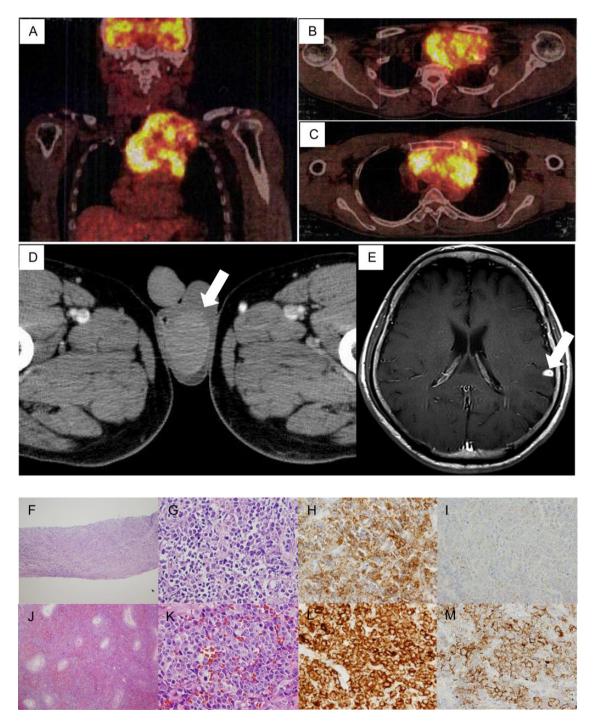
FDG-PET/CT showed remarkable FDG uptake in anterior mediastinum (A-C). CT revealed right testicular swelling (D). Head MRI showed multiple parenchymal invasions (E). Mediastinal sections at low (F) and high (G) magnifications showed diffuse infiltration of medium-sized tumor cells with scant cytoplasm and dense chromatin, which was accompanied by nuclear fragmentation. The tumor cells were positive for CD56 (H) and CD99 (I). Testicular mass sections at relapse showed diffuse stromal infiltration of medium- to large-sized atypical cells with no apparent differentiation to neutrophils or monocytes (J and K). The tumor cells were positive for MPO (L) and CD34 (M).
